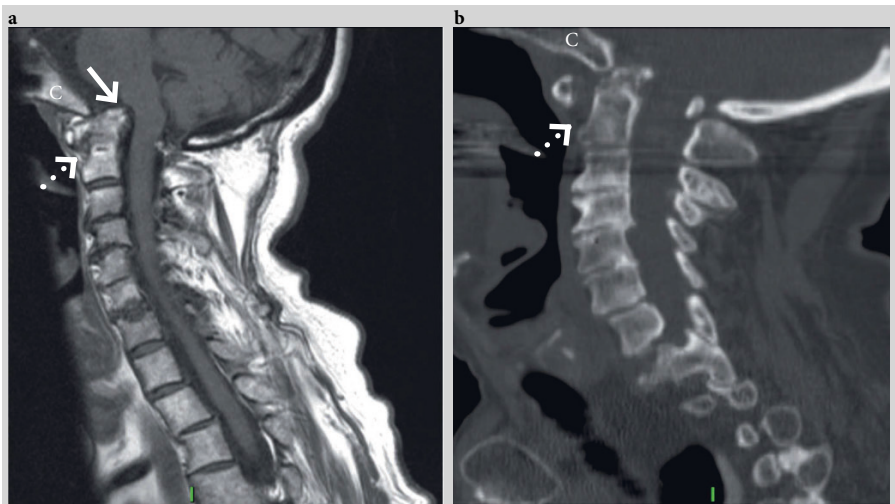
Basilar invagination and atlantoaxial subluxation. Sagittal T1 (a) and sagittal computed tomography (CT) (b) demonstrate classic findings of basilar invagination with the dens located cephalad and posterior to the tip of the clivus (C). The dens (arrows) indents the brainstem anteriorly on the left magnetic resonance image. There is widening of the distance between the anterior arch of C-1 and the dens which is seen clearly on the CT image (dotted arrows) (b).
